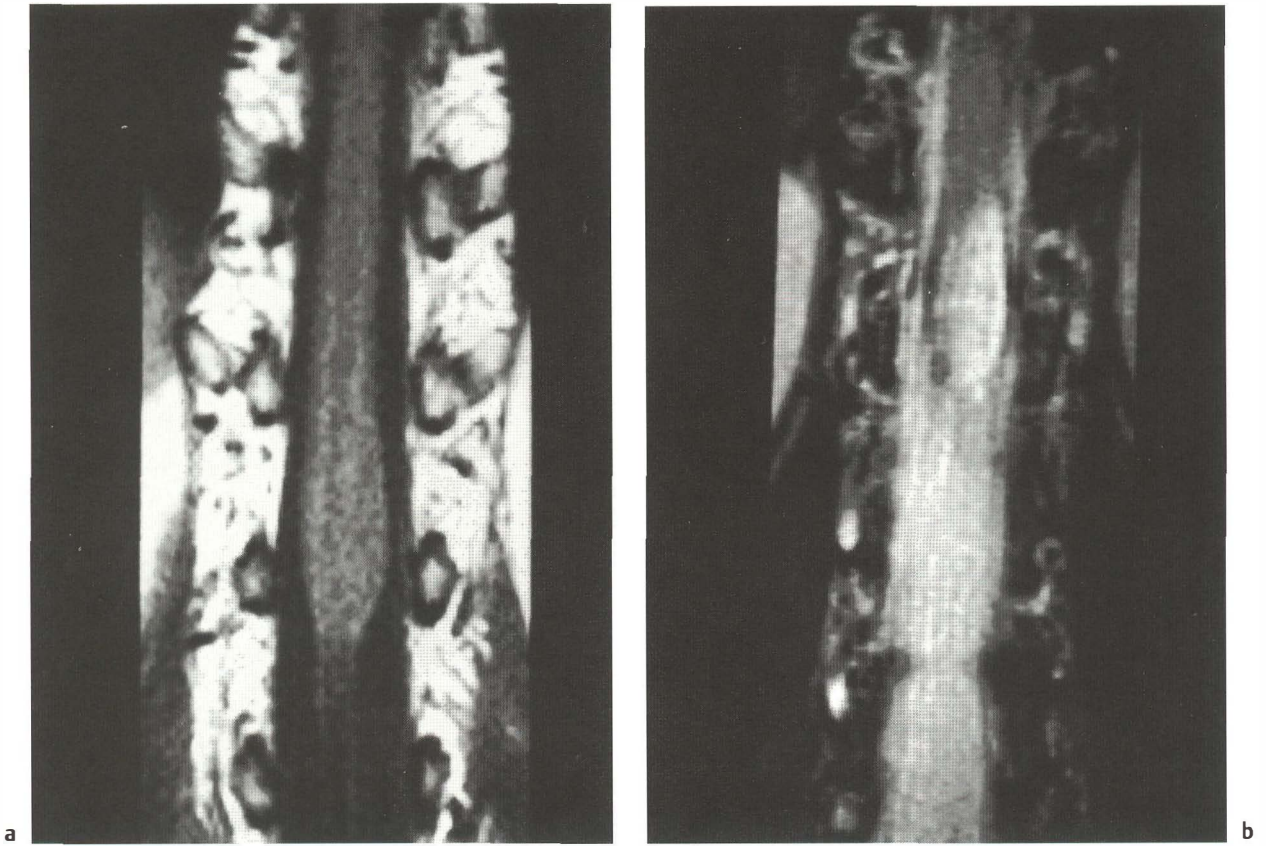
Grade III astrocytoma of the conus (case 100; same case as in Fig. 79). Coronal T1-weighted (a) and T2-weighted images (b). The T1-weighted image shows the morphological changes better, while only the T2-weighted image is able to demonstrate the precise tumor limits of this high-signal lesion, which did not enhance on the postcontrast T1-weighted image. c A sagittal T1-weighted image and d T2-weighted image are useful cuts that are complementary to the coronal images. e Axial T1-weighted image and f T2-weighted image. The T2-weighted image provides additional evidence of the eccentric left position of the tumor
